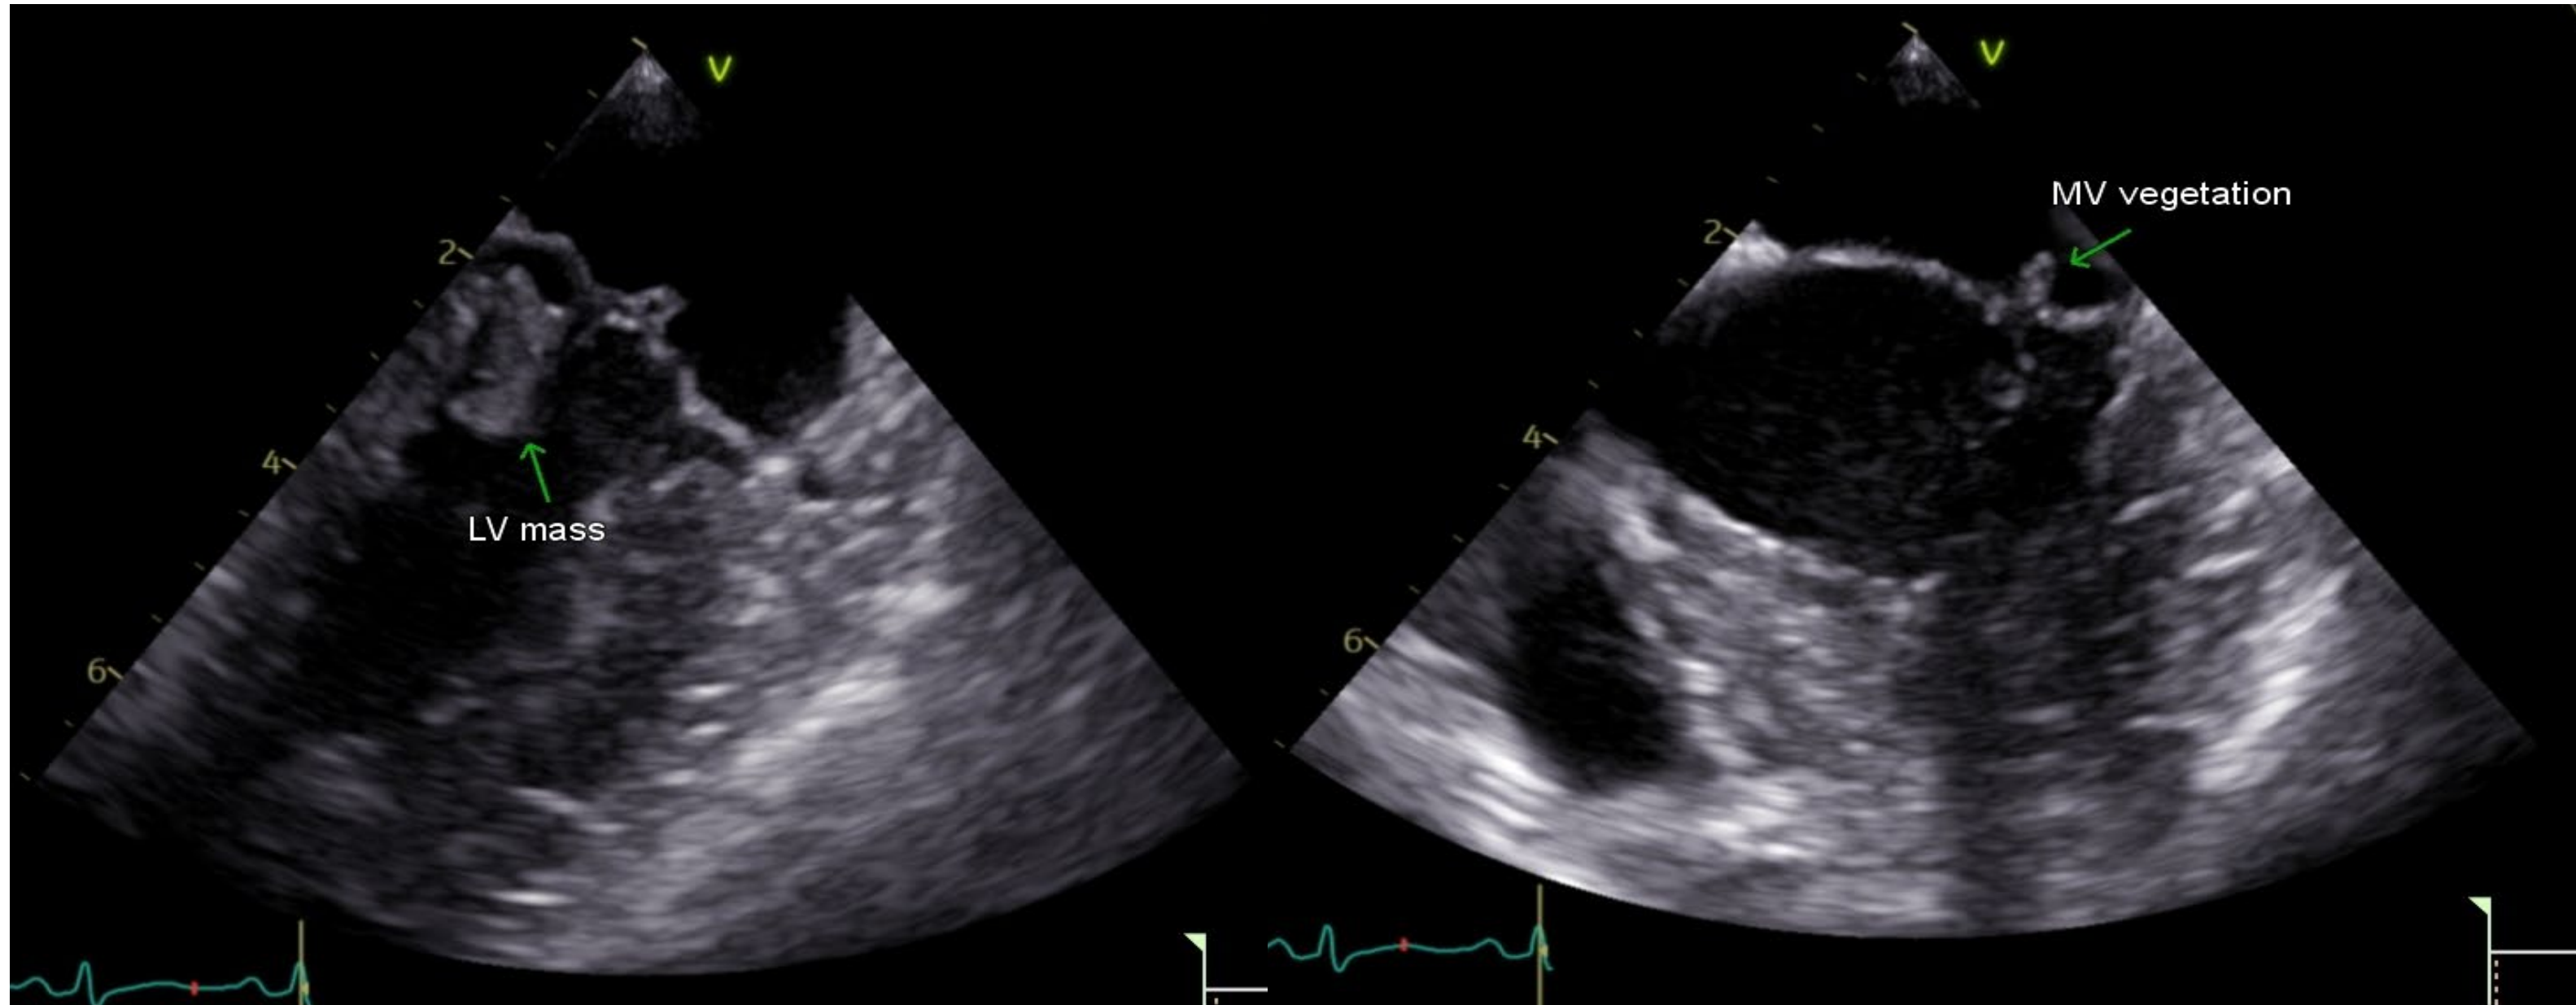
Transoesophageal echocardiography findings of left ventricular mass/thrombus and mitral valve vegetation
